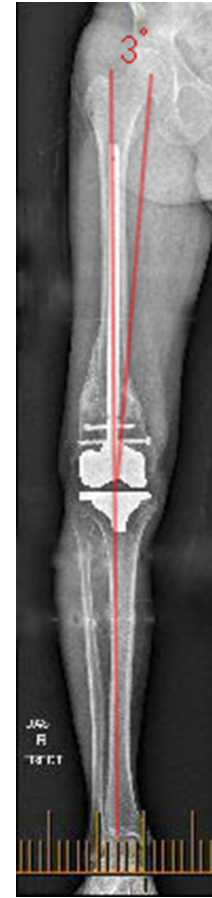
Anterior-posterior long-leg radiograph taken at 6 months postoperatively.
